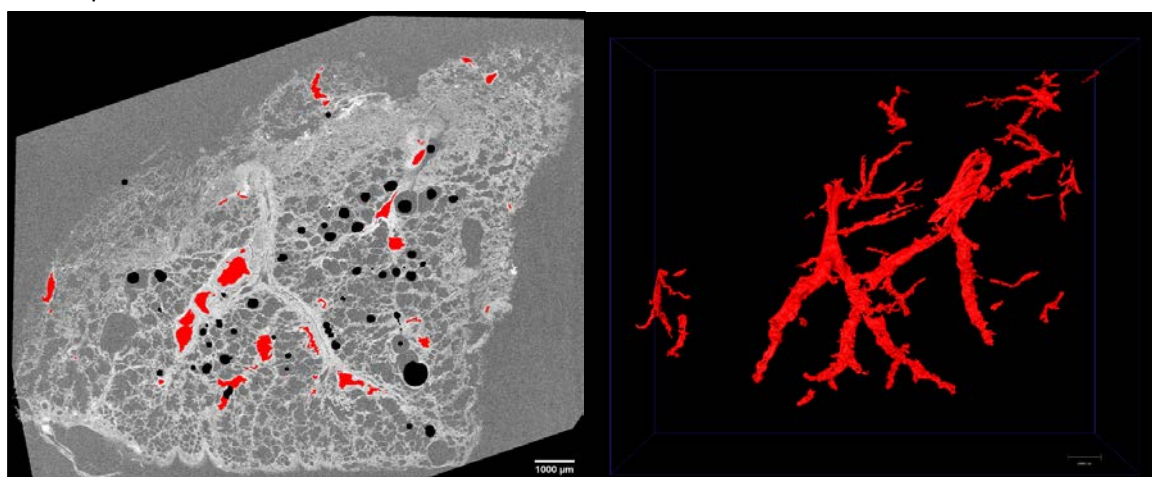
Exemplar segmentation of  $\mu$ CT dataset highlighting blood vessels (red) on a 2D plane and displayed as a 3D surface. The left image shows a 2D  $\mu$ CT slice which has been segmented to highlight the location of each blood vessel lumen in the image. This process was repeated over hundreds of images to build a network of 3D segmentation and is visualised as a 3D surface render in the right image.
